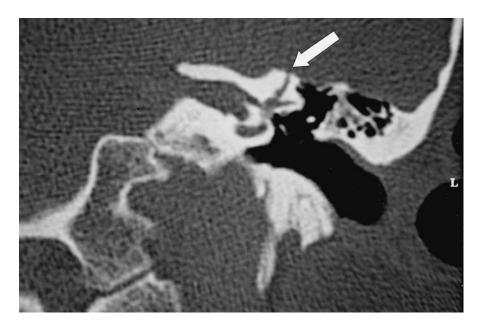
Superior canal dehiscence syndrome. High-resolution computed tomography scan of the petrous bone, coronal slice. There is a bony defect in the apical part of the superior canal extending toward the epidural space (*arrow*).
